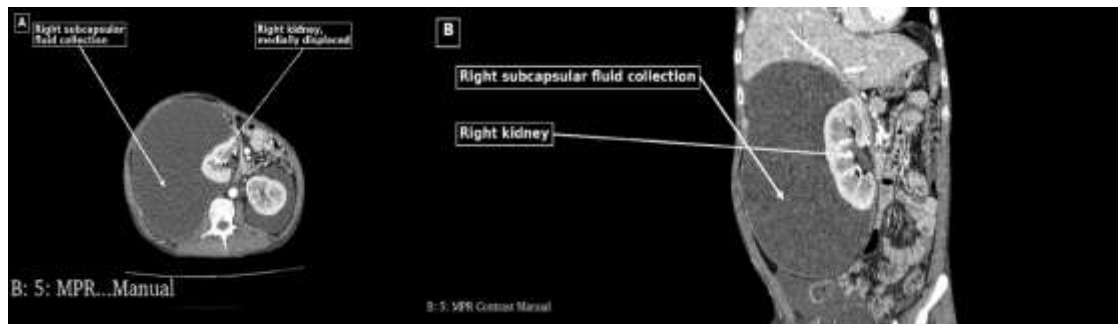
Contrast-enhanced abdominal computed tomography demonstrating a massive right renal subcapsular fluid collection. (A) Axial image showing the right subcapsular fluid collection and medial displacement of the right kidney. (B) Coronal multiplanar reconstruction showing the craniocaudal extent of the collection and its relationship to the right kidney
